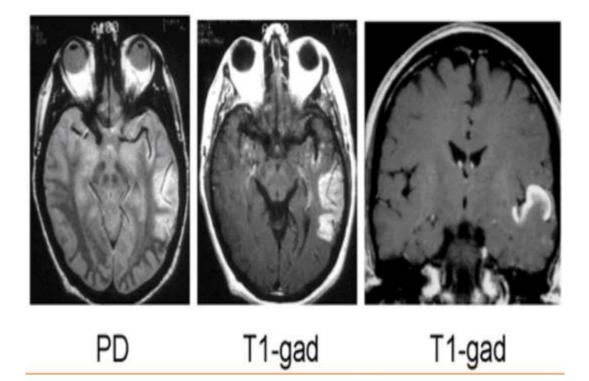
MRI subacute infarction
